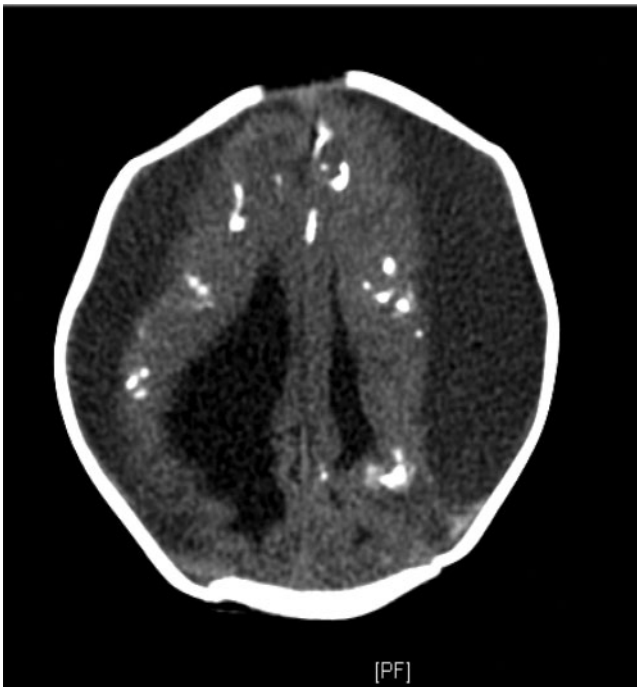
Brain CT scan of an infant with congenital toxoplasmosis, showing hydrocephalus, and diffuse parenchymal calcification. Courtesy of Dr Craig Shapiro.
